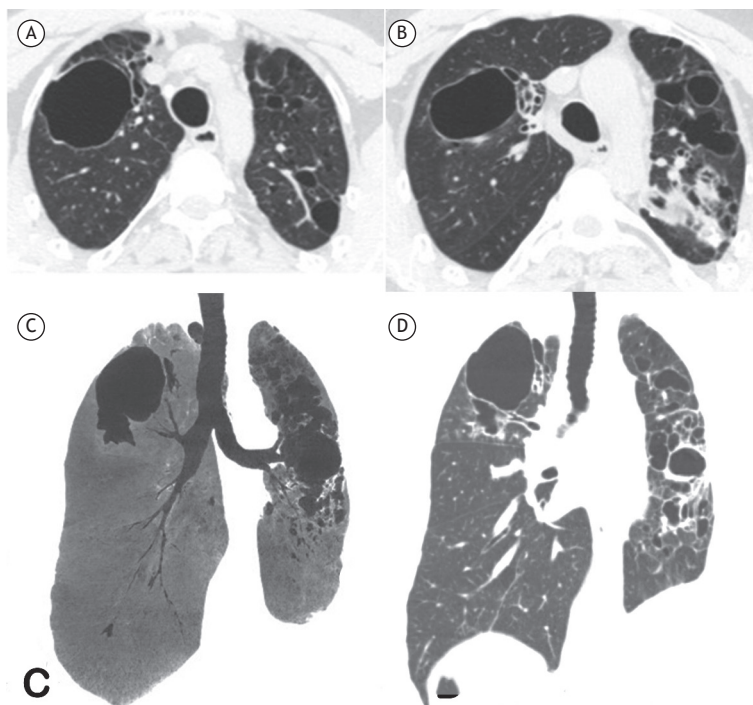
Axial CT scans of the upper lobes (in A and B) and a coronal reconstruction (in C) show bilateral thin-walled cavities and non-homogeneous consolidations in the left lung as well as bronchiectasis. A coronal reconstruction performed 10 months prior (in D) demonstrated similar findings.
